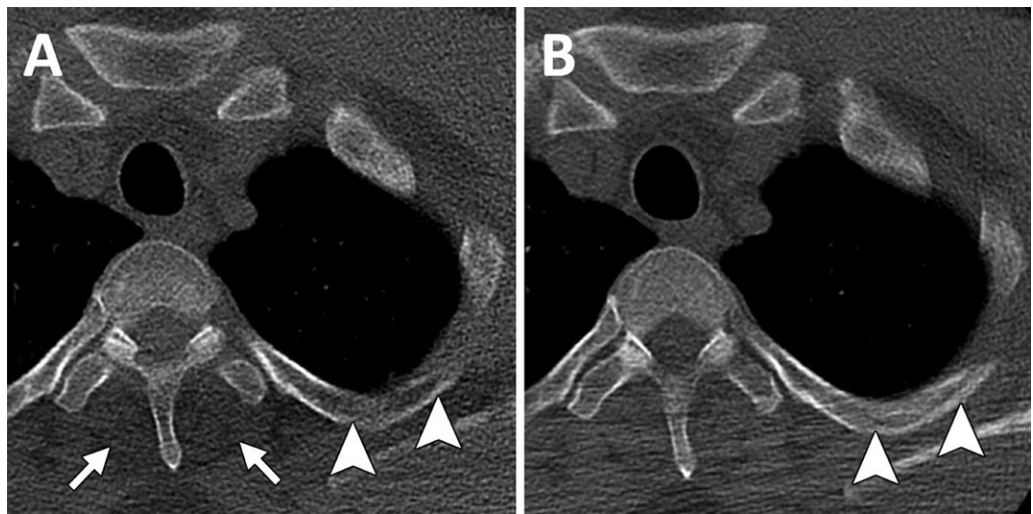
Effect of elimination of electronic noise. Example energy-integrating detector (EID) and photon-counting detector (PCD) CT images in 59-year-old man. A, EID image shows low-attenuation areas in paraspinal muscles (arrows) in lung apices due to beam hardening and electronic noise. Cortex of a left upper rib (arrowheads) appears eroded. B, PCD image at same level as A shows a more uniform appearance of the erector spinae muscles. Cortex of the upper left rib (arrowheads) is better visualized. Overall image noise is lower with PCD, as seen in the pectoral muscles. Images were acquired at identical settings and were reconstructed with similar algorithm and convolution kernels. (Reprinted, with permission, from reference 26.)
